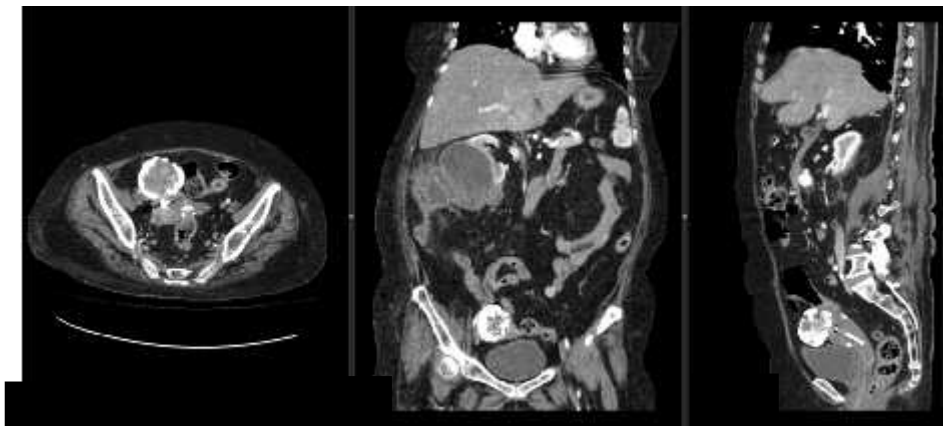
Abdominal CT axial (a), coronal (b), and sagittal (c) with contrast injection arterial phase shows calcification at the uterine (Arrow).
